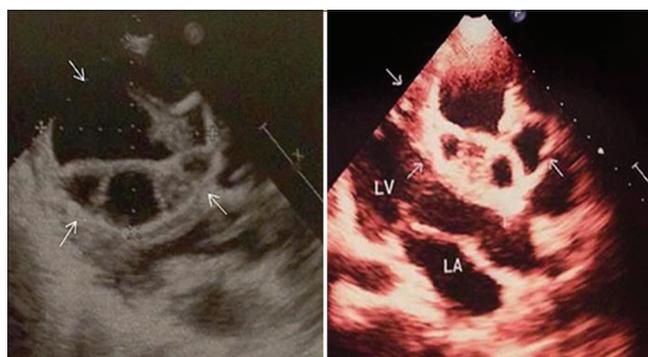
Echocardiography study depicts 67x65 mm sized left ventricular apical located multilocular cystic lesion with its internal echogenic septations (arrows)
